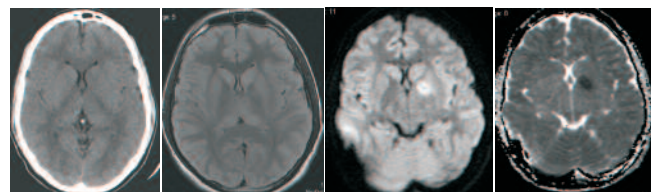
(a) Axial CT (b) FLAIR Axial (c) DWI Axial (d) ADC Map Axial
